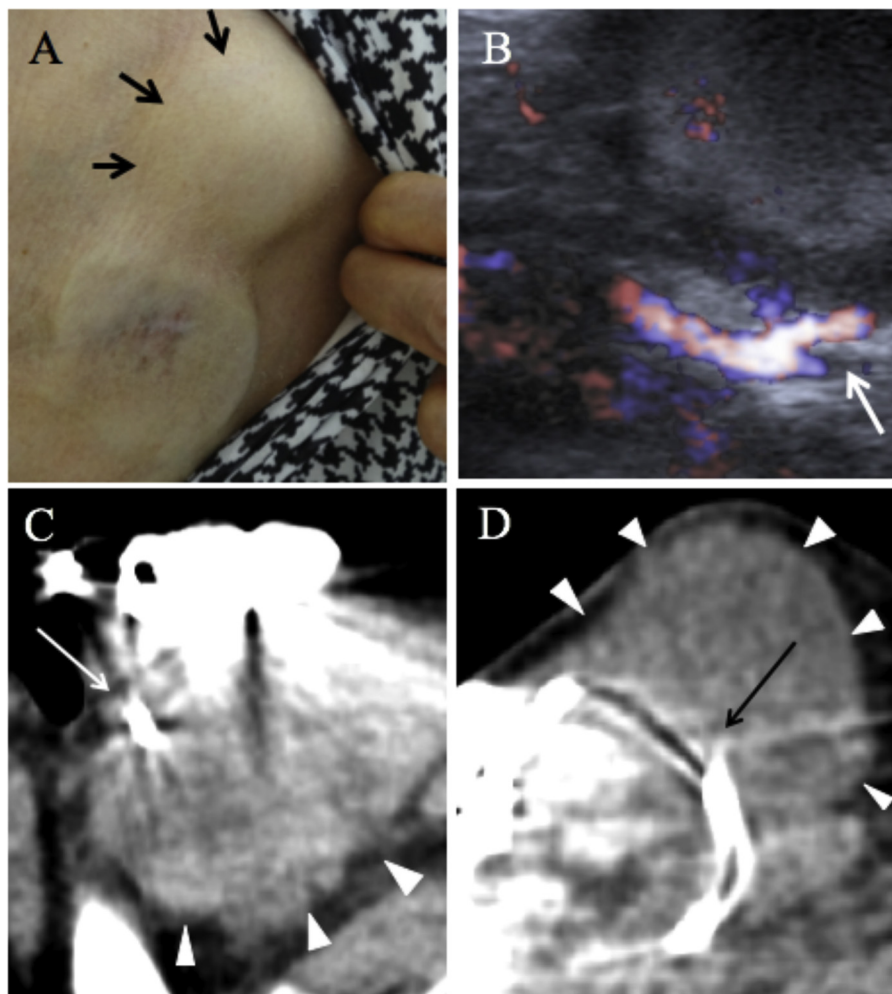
(A) Skin appearance. There is a painless 35-mm mass on her left chest (black arrows). (B) Ultrasonography reveals pulsatile blood flow from the subclavian artery into the mass (white arrows). (C, D) Plain computed tomography (C: axial view, D: coronal view). Pacing lead (black and white arrow) is involved in the mass (white arrow heads).
